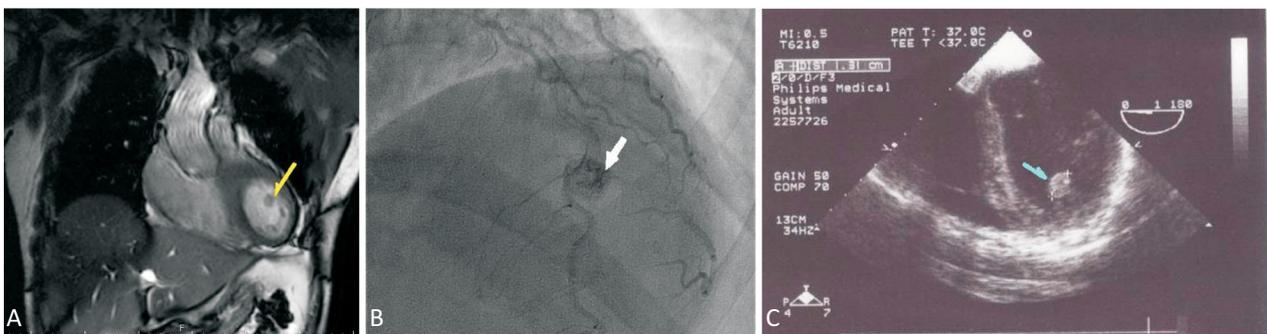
(A) A round mass on the lateral wall of the left ventricle showed isointense signal in T1-weighted image (arrow). (B) Coronary angiography showed that septal branches feed the tumor as a characteristic “tumor blush” (arrow). (C) Preoperative transesophageal echocardiogram revealed a homogenous round mass (arrow) with a pedicle that originated from the lateral wall of the left ventricle.
